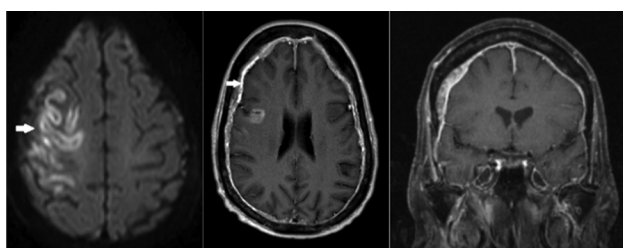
MRI Axial T1 Flair C+ post gadolinium contrast..
